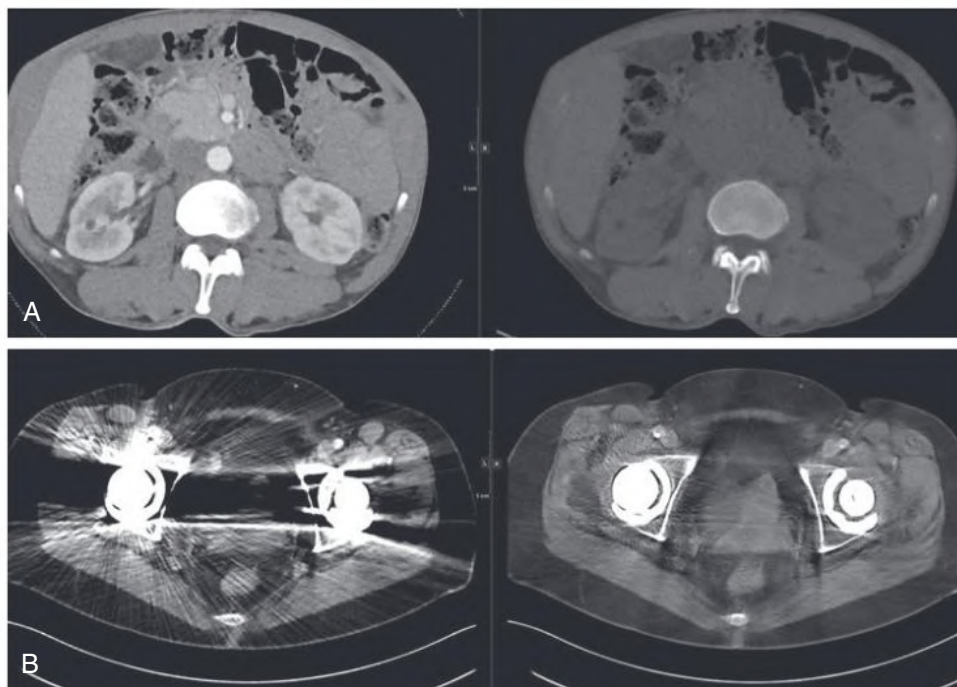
(A) Following only one postcontrast computed tomography (CT) acquisition with dual energy, mathematical algorithms are used to obtain two sets of images. On the left is the standard postcontrast image, and on the right is the virtual noncontrast calculated image. (B) New CT software postprocessing permits much more diagnostic image quality with metal artifact reduction. The usual image obtained is at *right*, and the image using metal artifact reduction is at *left*.
